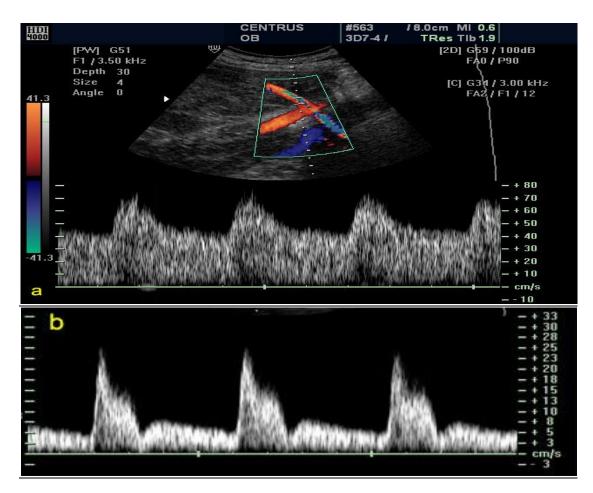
(a,b): Doppler spectra of uterine artery flow. (a) The color flow image allows beam/flow angle visualization. The sonogram shows high velocities throughout the cardiac cycle, indicating low distal resistance. (b) The sonogram shows a pulsatile flow waveform with low diastolic velocities. This is indicative of high distal resistance.
